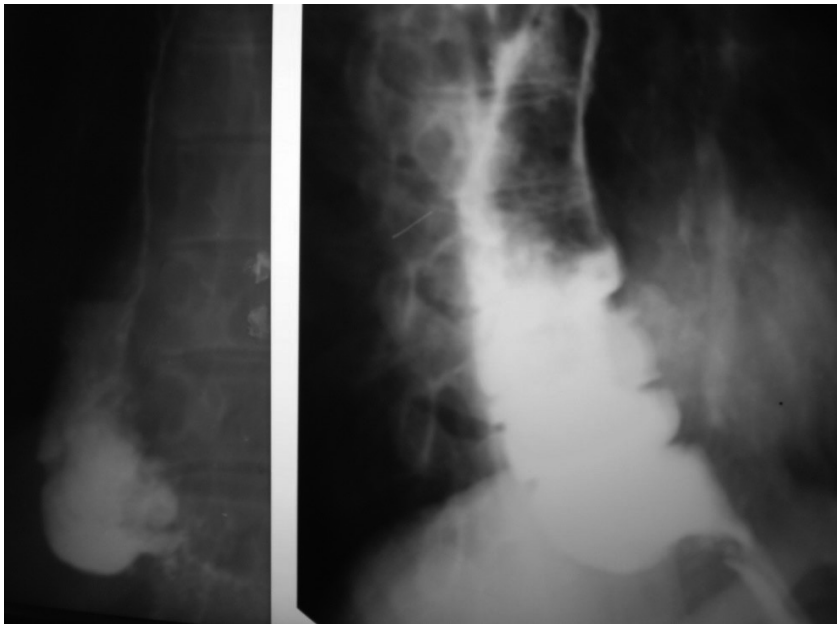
X-ray examination of the esophagocoloplasty segment
